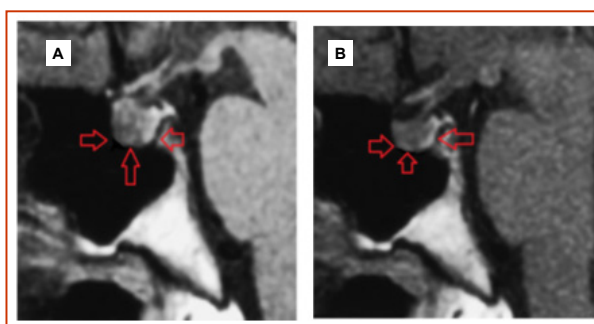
Magnetic Resonance Imaging (MRI) of the sella
